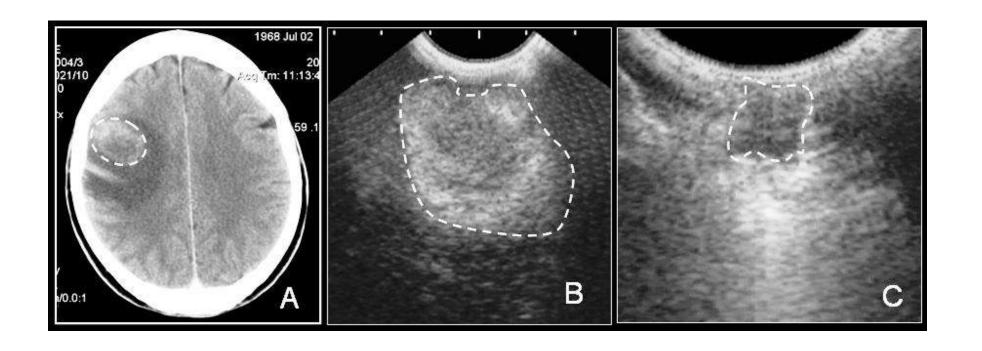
(A) An axial CT scan of a high grade glioma showing a peripherally enhancing mass in the posterior frontal region with central necrosis and marked peripheral oedema. (B) The axial IOUS done soon after opening the dura. The mass is hyperechoic with a central hypo-echoic area corresponding to the central necrosis seen on the CT scan. The margins are well defined. (C) IOUS after complete removal of tumor.
